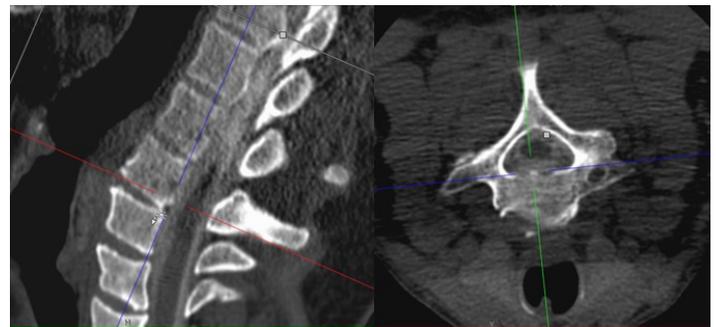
CT myelogram shows ventral collection of contrast at C7 in a configuration most consistent with extravasation into the epidural space. This is adjacent to a small right paracentral slightly spiculated calcified disc or osteophyte at the C6-7 level.
